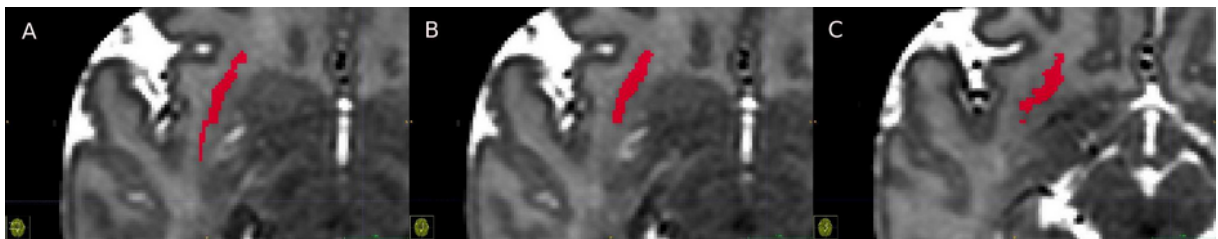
Ventral axial MRI slices with manual claustrum segmentation.
